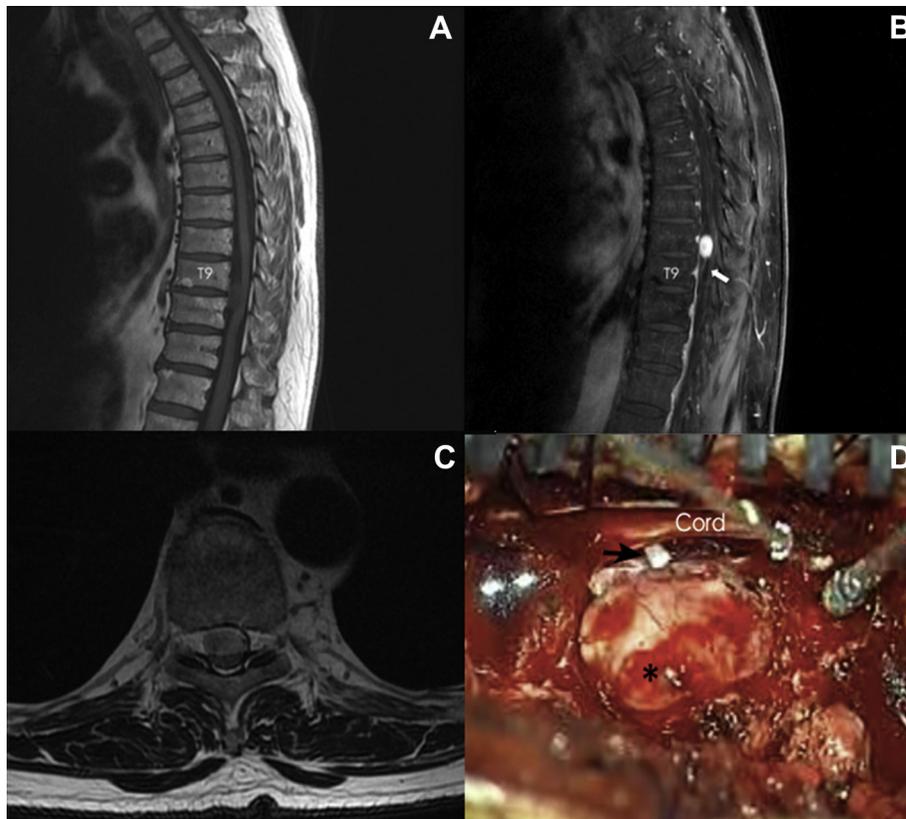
(A) A schwannoma is seen as an isointense mass between the T9–T10 levels over the ventral side of the thoracic cord on T1WI. (B) Another T1 scan with contrast enhancement 9 days later shows a well-encapsulated, homogeneous enhanced mass with a root origin (white arrow) movable over T8. (C) The spinal cord is compressed considerably by the ventral midline schwannoma in axial T2WI. (D) Gross picture of the thoracic spinal schwannoma with root connection (asterisk: tumor; black arrow: root). T1WI = T1-weighted image; T2WI = T2-weighted image.
